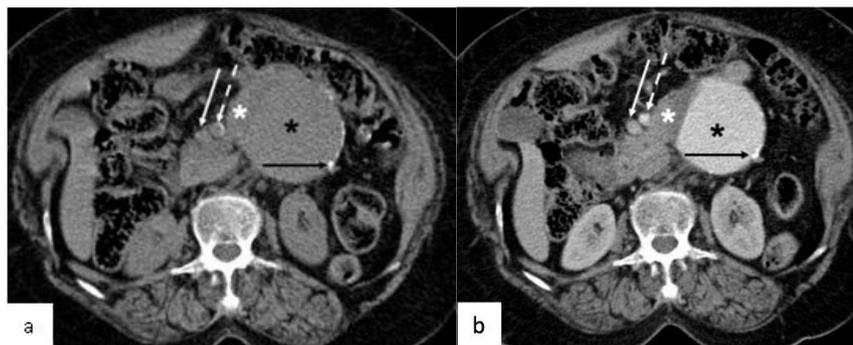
Non-contrast (a) and contrast-enhanced (b) CT images of the abdomen of an 87-year-old female show a large abdominal aortic aneurysm (black asterisk). Calcification (solid black arrow) is seen along the wall of the abdominal aorta. The contrast-filled true lumen of the aneurysm (black asterisk) appears hyperdense in Figure 8b. The non-enhancing hypodense area on the right side of true lumen (white asterisk) is thrombus. Solid and dashed white arrows point to the SMV and SMA, respectively. Note calcification along the wall of the SMA
